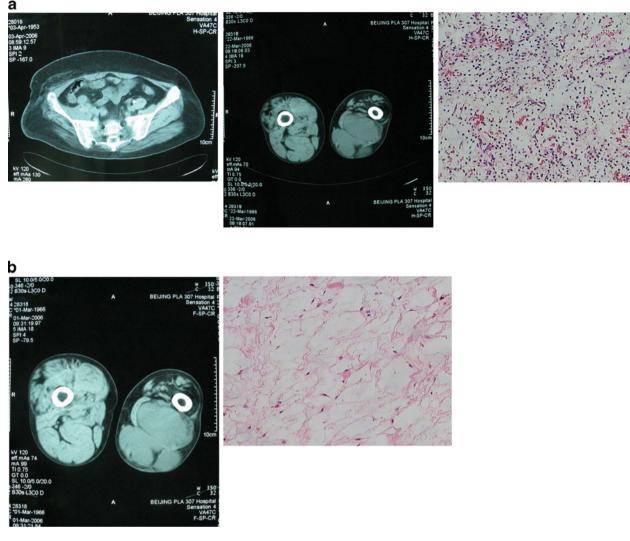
Liposarcoma case 3: A male with a myxoid liposarcoma in the leg thigh. After chemotherapy twice, chemo-response zone was form around the tumor and tumor tissue necrosis. (a) CT and pathological image before chemotherapy; (b) CT and pathological image after chemotherapy
